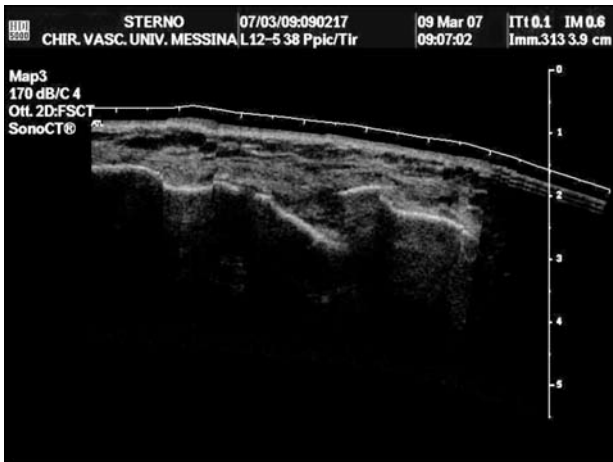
Ultrasonographic evaluation of displaced fracture.
